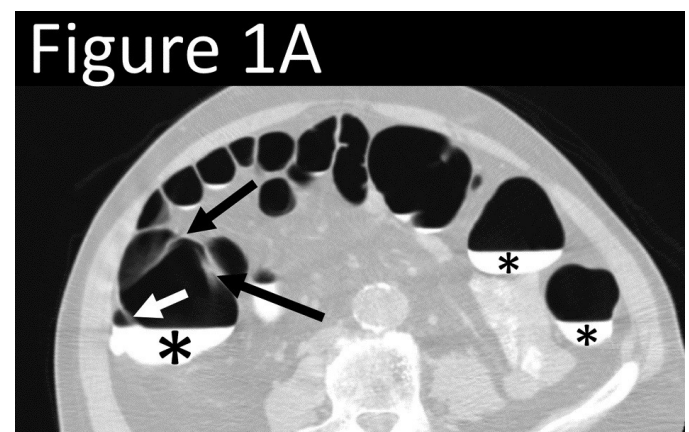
Axial CT-Colonography image demonstrating dependent fluid tagging (\*) obscuring a dependent haustral fold (white arrow) with a pair of unobscured, non-dependent haustral folds (black arrows). Note: difficulty in visualization of haustral fold pair due to slice selection in the axial plane.
